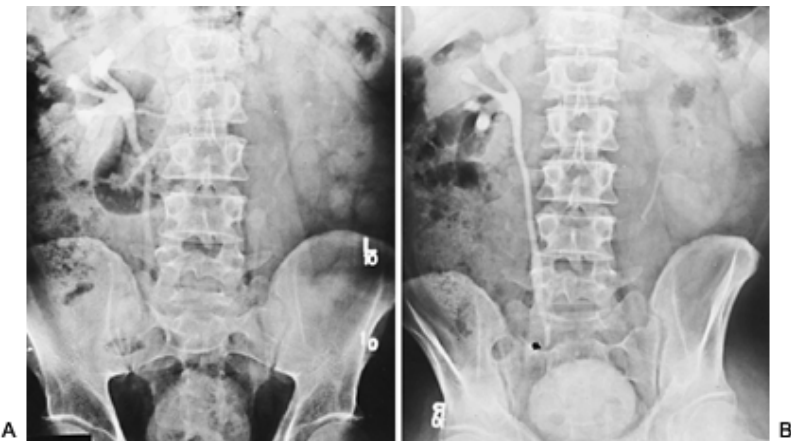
23. A: Ten-minute radiograph in a patient with right renal colic. There is hydronephrosis and dilation of the ureter with poor definition of the level of the obstruction. B: Prone radiograph demonstrates excellent opacification of the ureter with identification of the level of the obstruction (*arrow*).
